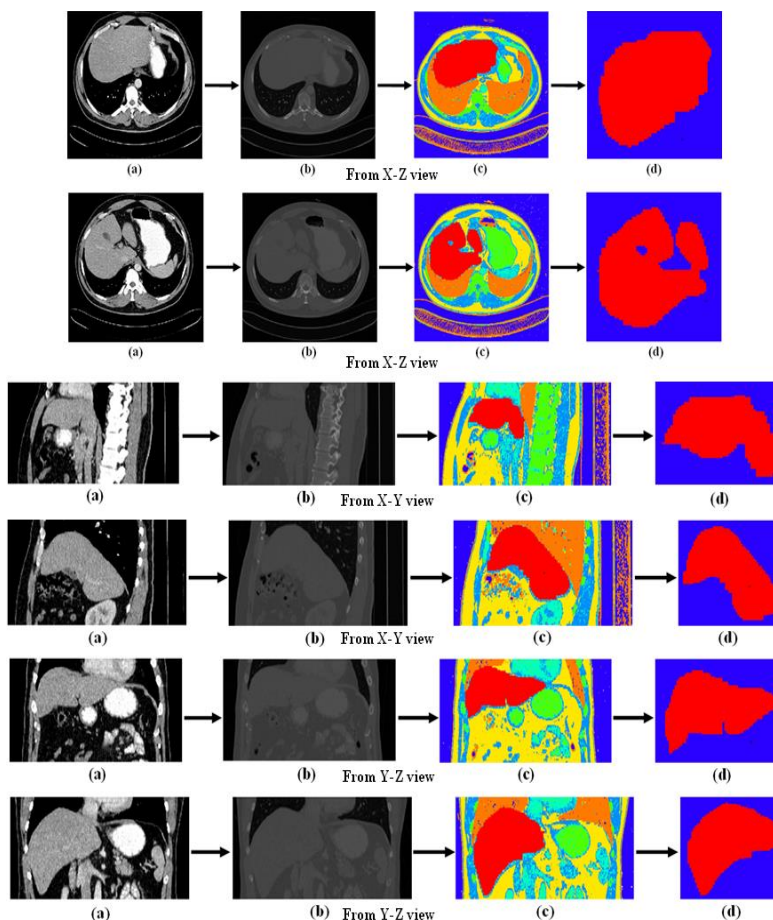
(a) Image of abdominal tissue slice using computed tomography scanning, (b) Image of abdominal tissue converted by MATLAB from computed tomography image, (c) Image of abdominal tissue converted by MCNPX from MATLAB , (d) Image of separated segmented liver tissue shown by MCNPX
